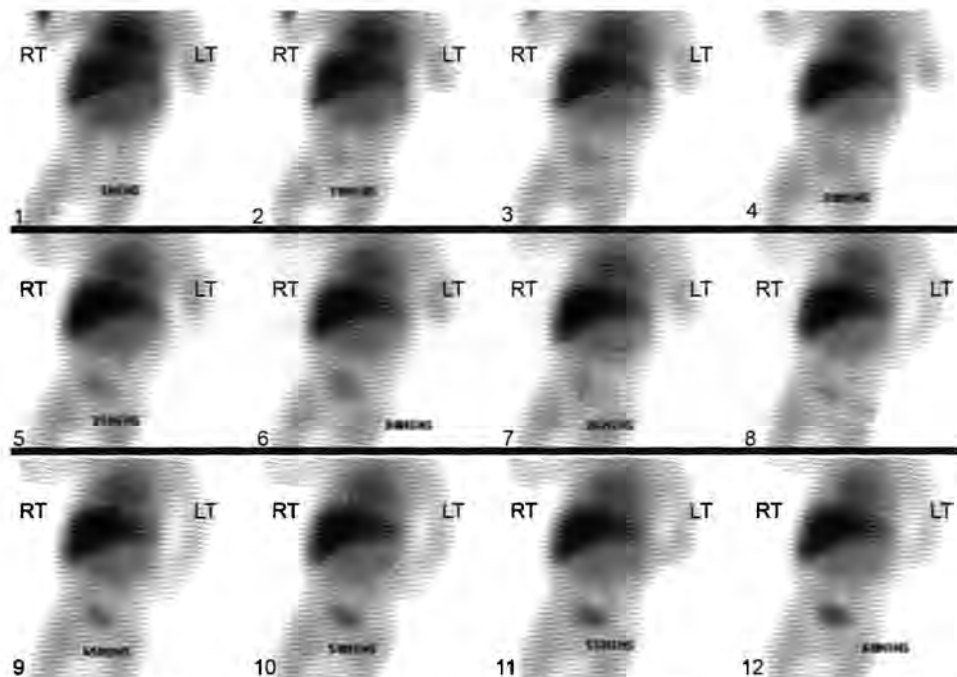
Sequential dynamic images of Tc-99m Mebrofenin hepatobiliary scintigraphy exhibit persistent retention of tracer in the liver and no radiotracer excretion in the intestinal track which may be seen with neonatal jaundice versus biliary atresia. However, static image of the abdomen image after 24 hours demonstrates absence of radiotracer in the bowel. The findings are concerning for biliary atresia.
